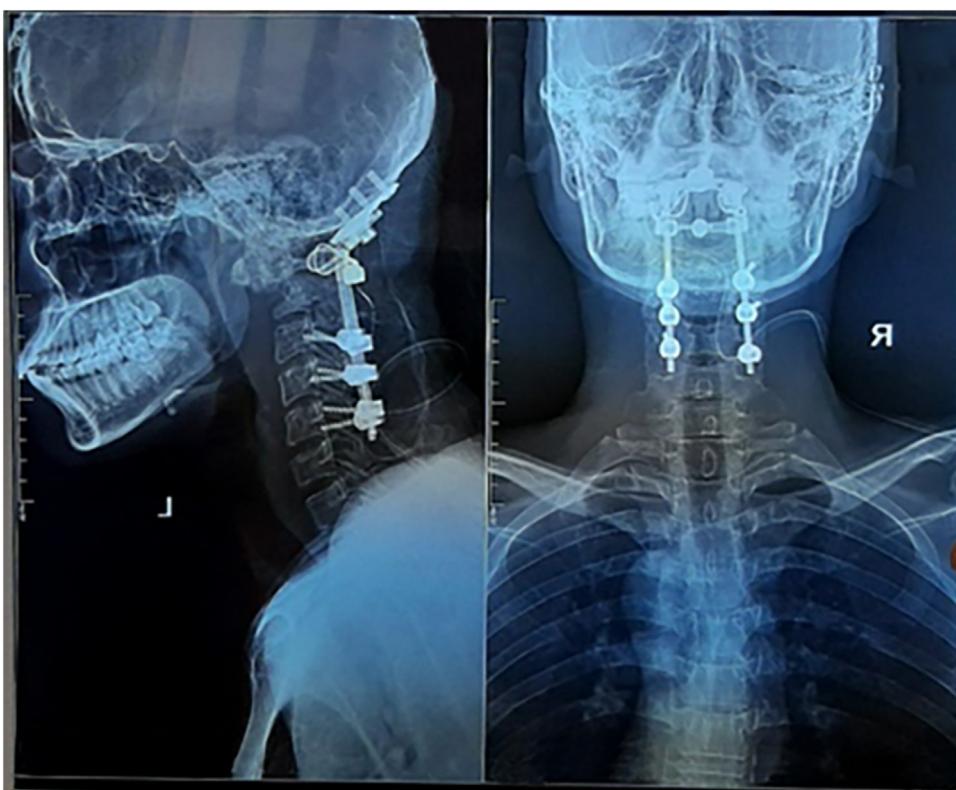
Postoperative plain x-ray showed plate, screw, rod, nut, and wire in cervical spine.
